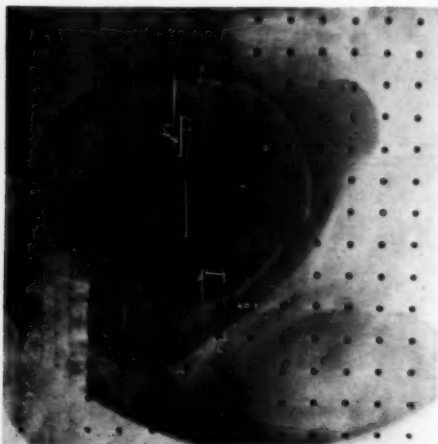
Centimeter grid roentgenogram of the pelvic inlet, showing the molded compressed fetal head somewhat below engagement.
